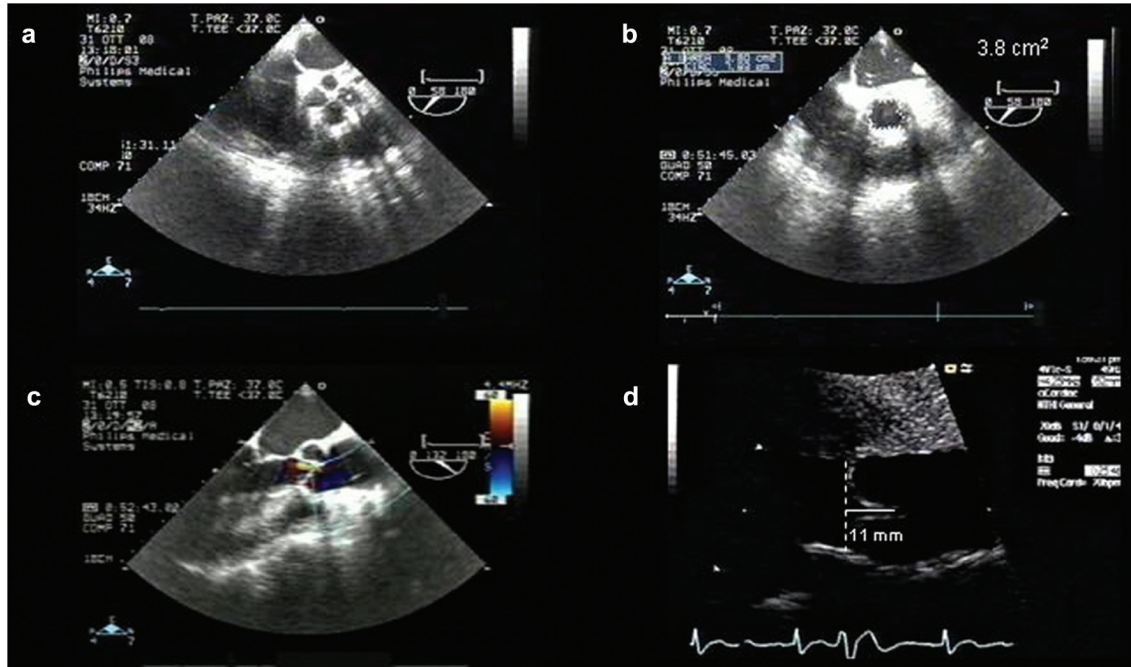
(a) Pre-repair intraoperative trans-esophageal short-axis view of the aortic valve during diastole. Four unequal size cusps are present; (b) post-repair intraoperative trans-esophageal short-axis view of the aortic valve during systole showing bicuspid morphology and normal aortic orifice area (measured 3.80 cm^2); (c) post-repair intraoperative trans-esophageal long-axis diastolic view showing trivial central jet regurgitation at Doppler interrogation; (d) follow-up trans-thoracic para-sternal long-axis view during diastole documenting effective height of leaflet coaptation (measured 11 mm).
